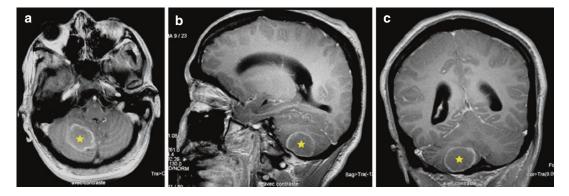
Axial (a), sagittal (b), and coronal (c) T1-weighted MRI after gadolinium injection revealing a cerebellar tuberculoma (*star*) in the right side (case $n^{\circ}2$)
